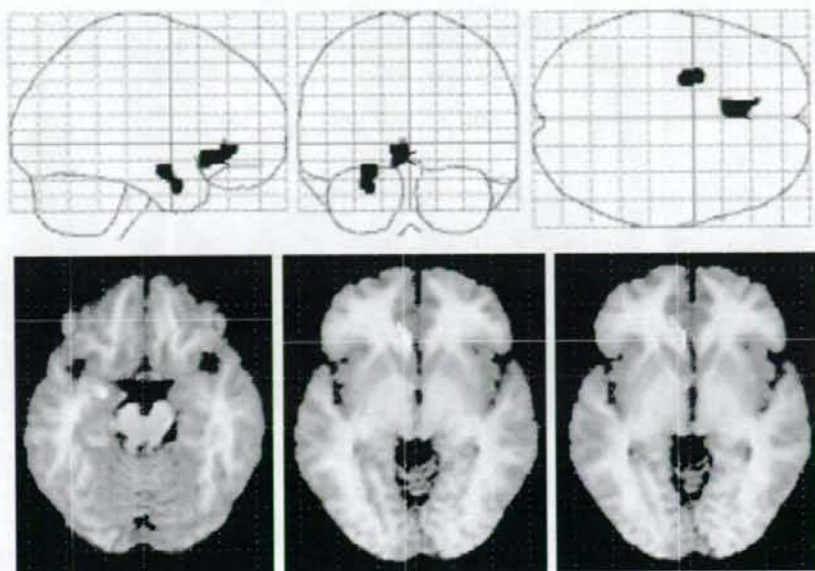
Results of genotype-diagnosis interaction effects on brain morphology. *Top:* The SPM $\{t\}$ is displayed in a standard format as a MIP. The stronger effects of Val158Met polymorphism on brain morphology in schizophrenia than those in controls were noted in the left ACC, left parahippocampal gyrus and the amygdala-uncus. *Bottom:* The SPM $\{t\}$ is displayed onto axial T₁-weighted MR images.
